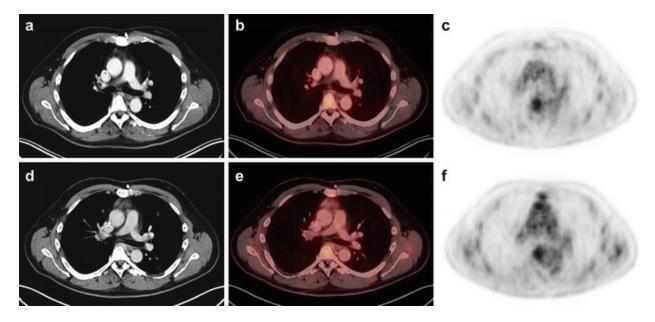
48 year old male patient suffering from metastatic rectal cancer undergoing PET/CT for wholebody tumor staging. Morphological CT, fused PET/CT and PET images are displayed before $(\mathbf{a}-\mathbf{c})$ and after chemotherapy $(\mathbf{d}-\mathbf{f})$. After treatment, a new mass in the anterior mediastinum with a faint tracer uptake can be observed, indicating thymus rebound
